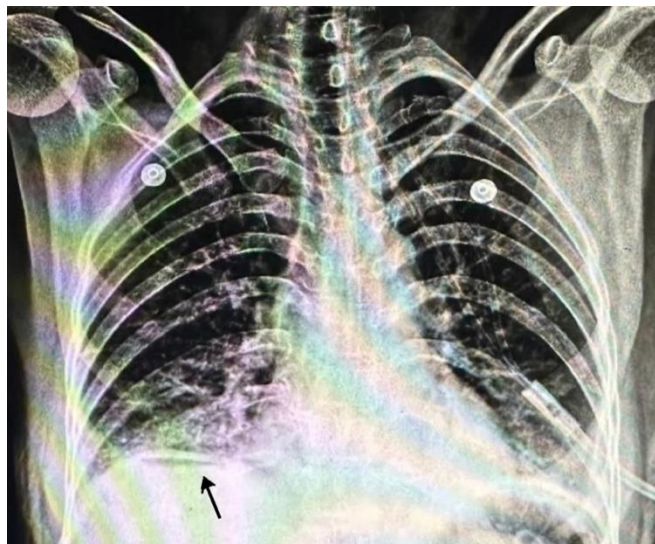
X-ray Erect Abdomen showing Gas under Diaphragm.
